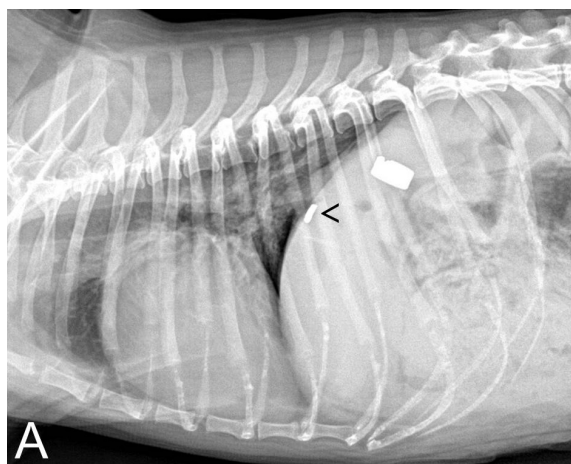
Postoperative lateral (A) and ventrodorsal (B) radiographs after constrictor placement: the constrictor is located caudal to a haemoclip (arrow head) used to secure the cellophane band on the first surgery
